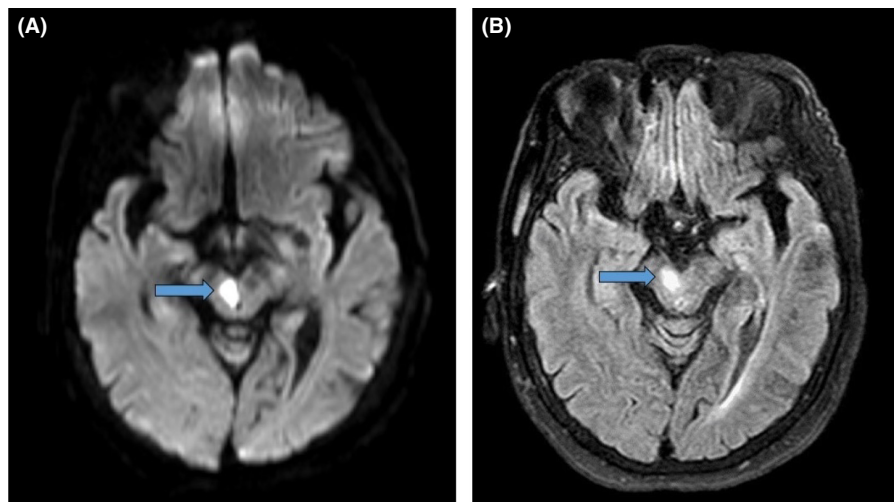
MRI head showing hyperintense lesion on FLAIR weighted image in the right paramedian midbrain (arrows) involving the tegmentum, including the red nucleus. FLAIR, fluid-attenuated inversion recovery
